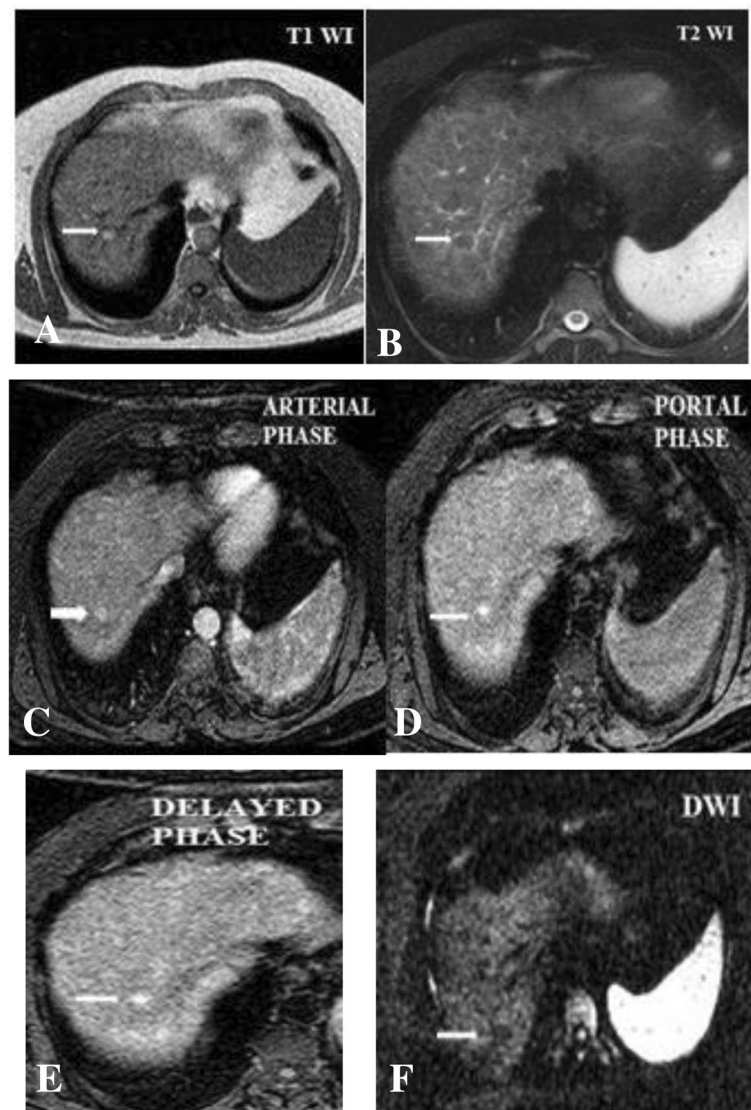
A 54-year-old male presented with loss of appetite. a An axial unenhanced T1W image shows the right lobe segment IV focal lesion of high signal intensity (arrow). b An axial T2W image shows a lesion of low signal intensity (arrow). c An axial post-contrast arterial phase image showed homogeneous contrast uptake (arrow). d, e An axial portal and delayed images showed persistent contrast enhancement (arrow). f DWI shows the lesion to be of low signal due to non-restricted diffusion (arrow) with an ADC value of $0.7 \times 10^{-3} \text{ mm}^2/\text{s}$. Suggested MR diagnosis: dysplastic nodule. Biopsy results: high-grade dysplastic nodule
